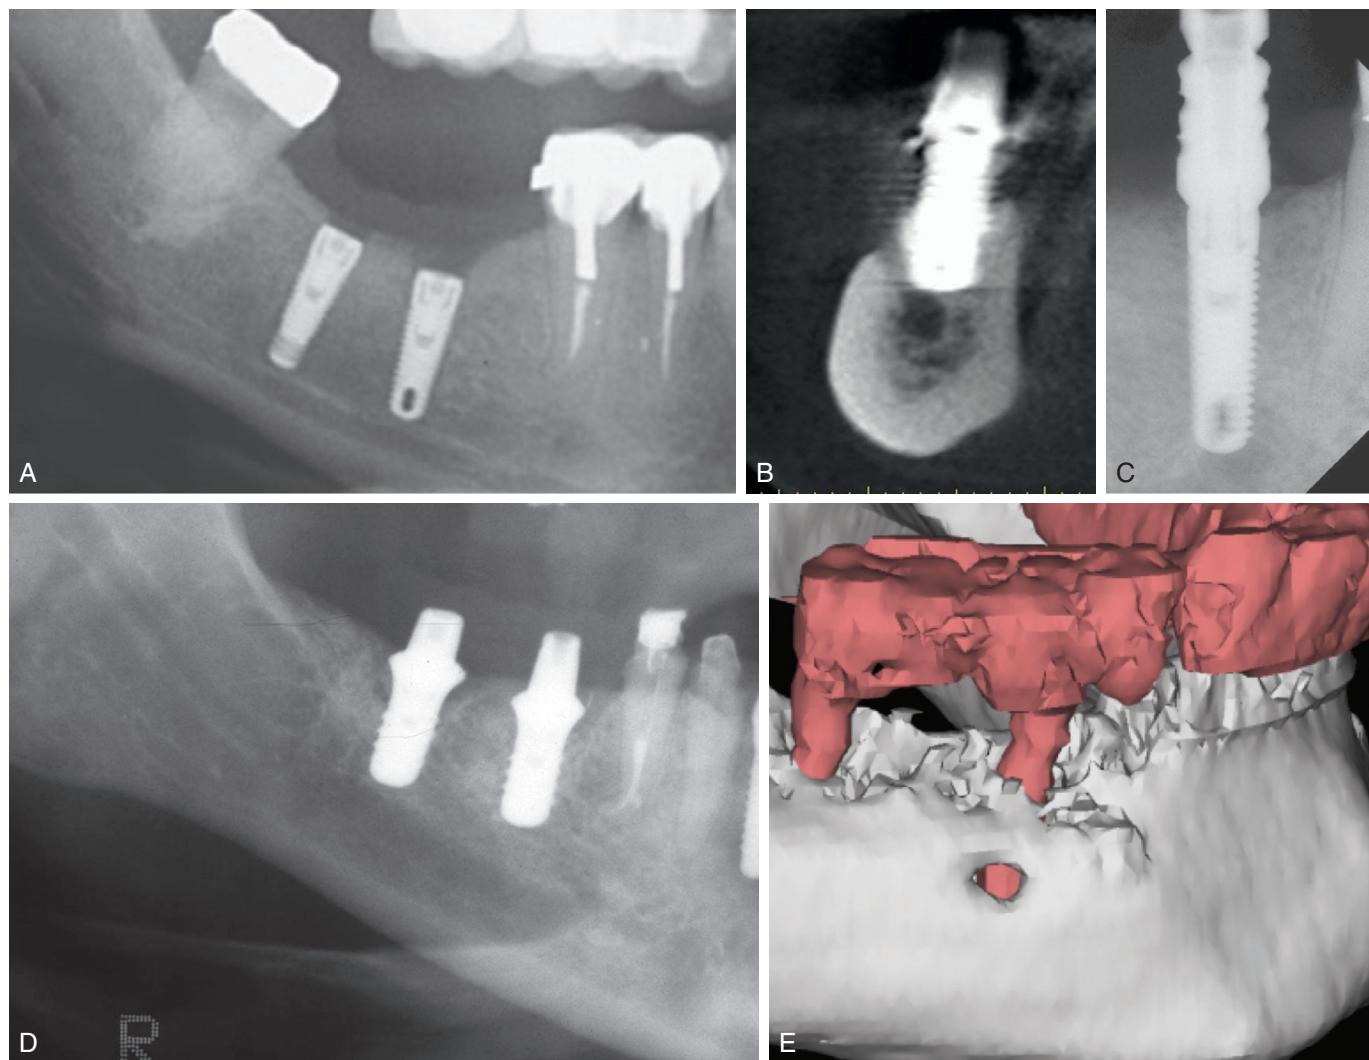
Neurosensory impairment of the inferior alveolar nerve. (A) Placement of two implants, completely transecting the mandibular canal. (B–C) Implant placement impinging on the mental foramen. (D) Immediate placement implant after premolar extraction causing nerve impairment. (E) CBCT image depicting implant placement through mandibular canal.
